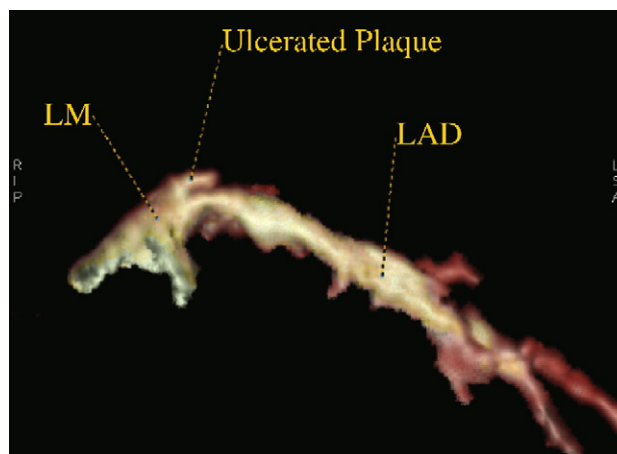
CT-scan volume rendering image with distal left main ulcerated plaque.
